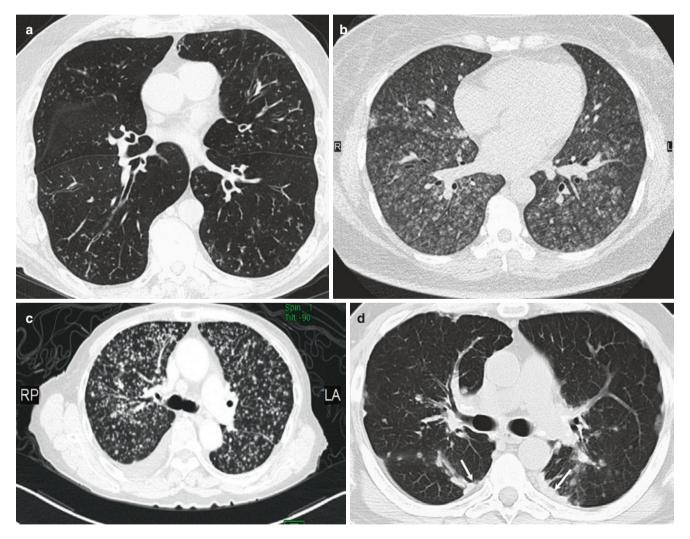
Diffuse nodules. (a) Axial CT image shows centrilobular nodules and tree-in-bud opacities. (b) Axial CT images showing centrilobular nodules from subacute hypersensitivity pneumonitis. (c) Randomly
